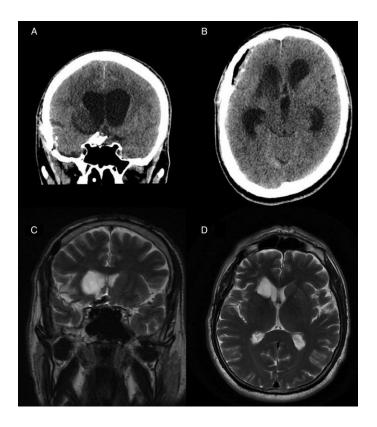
Coronal (A) and axial (B) CT demonstrating right caudate nucleus, anterior limb or internal capsule, and putaminal infarct extending into the region of the nucleus accumbens. T2-weighted MR coronal (C) and axial (D) images in a different patient demonstrate a similar pattern.
